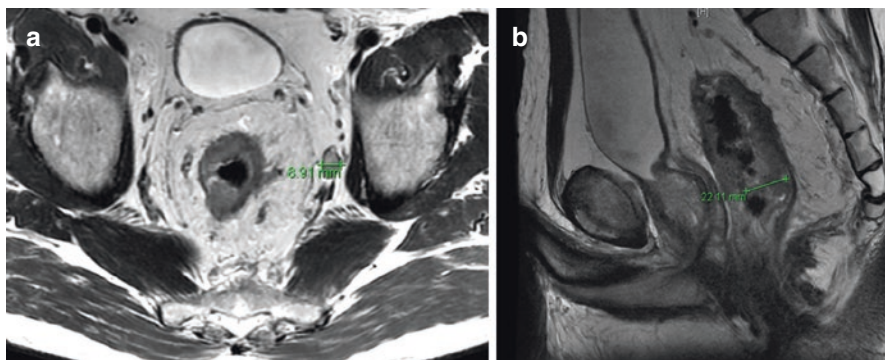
(a, b) Magnetic resonance imaging in rectal cancer staging. Routine use of rectal MRI in the context of a multidisciplinary assessment of rectal cancer has been used to plan neoadjuvant therapy and surgery and has been shown to reduce the incidence of positive circumferential margins. Axial and sagittal views of a locally advanced rectal cancer are shown, depicting extramural venous invasion and enlarged obturator lymph nodes
